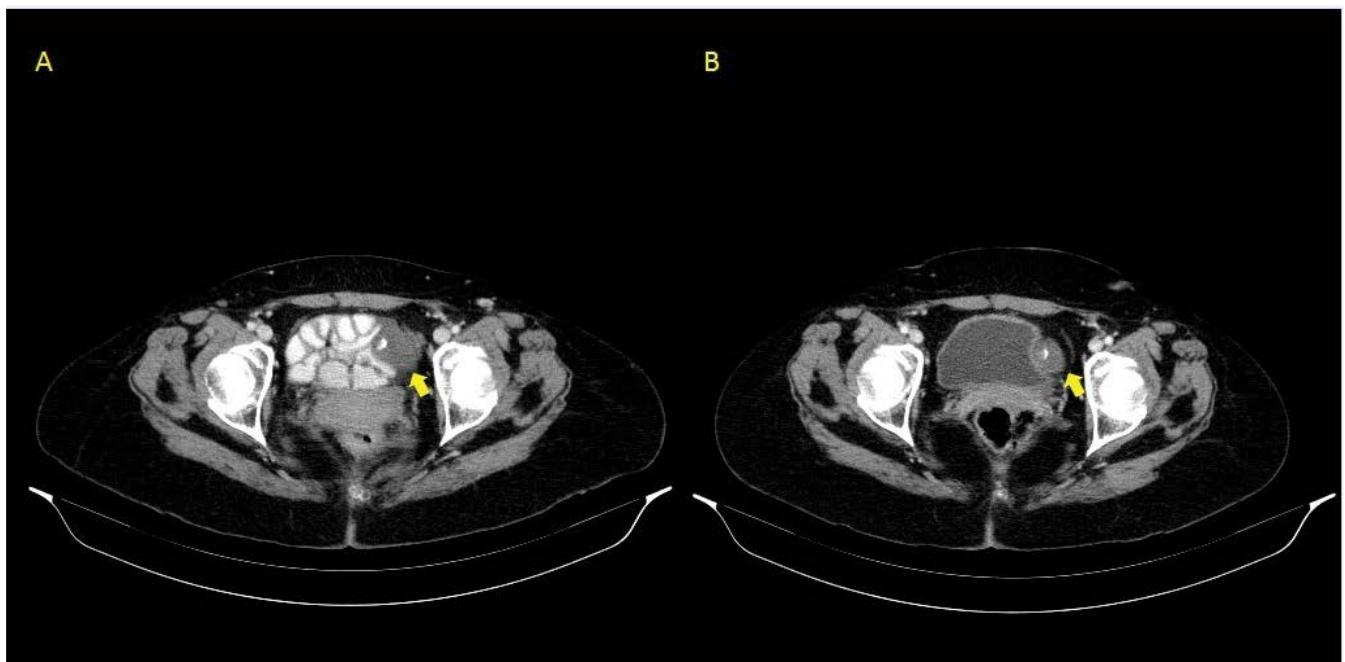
(A) CT scan showing the pelvic parauterine recurrence (arrow), (B) CT scan showing the response (arrow) of the pelvic recurrence to double immune checkpoint blockade with ipilimumab and nivolumab, after 3 cycles.
